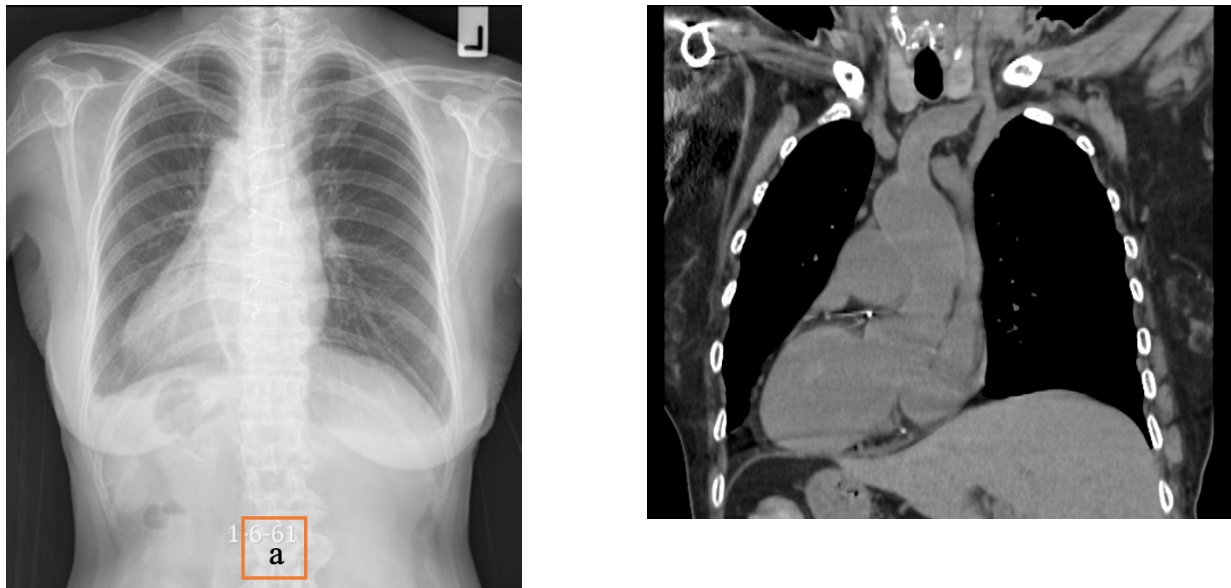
a. Chest X-ray image showing dextrocardia. b. Chest computed tomography image in the coronal plane showing dextrocardia.
